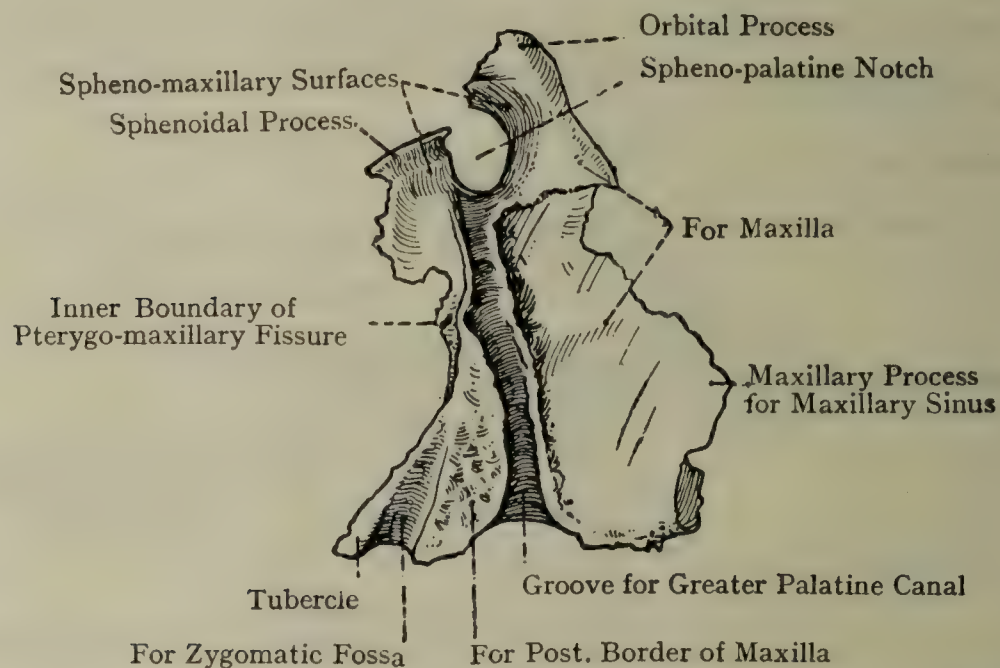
THE RIGHT PALATINE BONE (LATERAL ASPECT).
